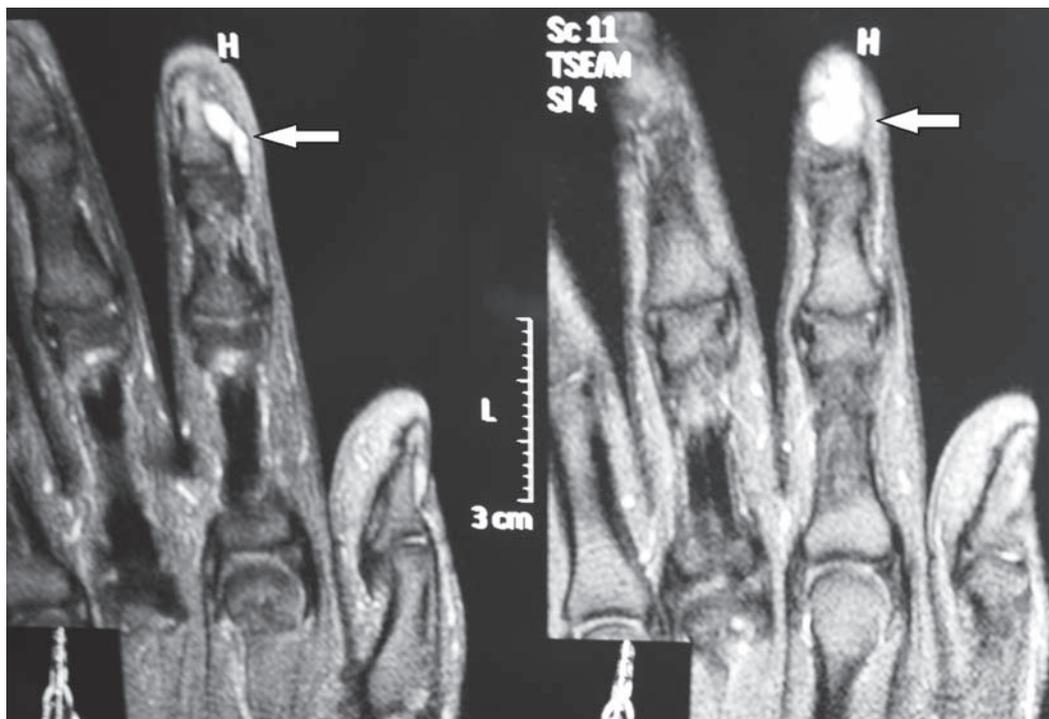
MRI findings in the coronal view of the distal phalanx showed a mass at the subungual area and adjacent to the distal phalanx.
